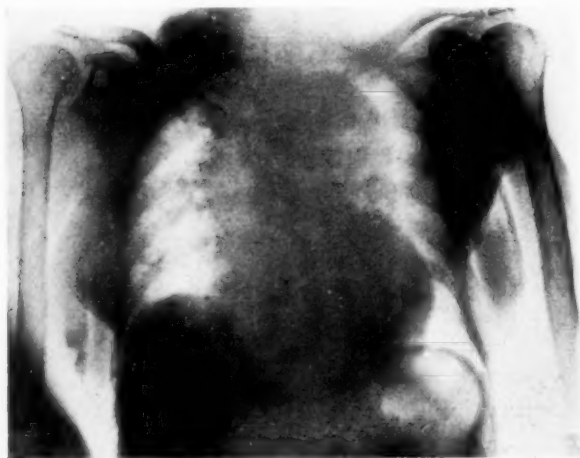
X-ray of the chest showing an aneurysmal dilatation of the aorta with calcified areas in the ascending aorta and aortic arch.
